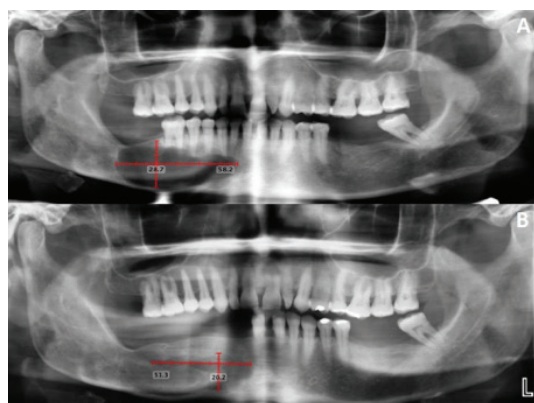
A- The longest mesio-distal and cranio-caudal distances of the mandibular cystic lesion were measured on panoramic radiography pre-operatively B- Post-operative panoramic radiography was taken at the end of 1 year follow-up period with same measurements.
